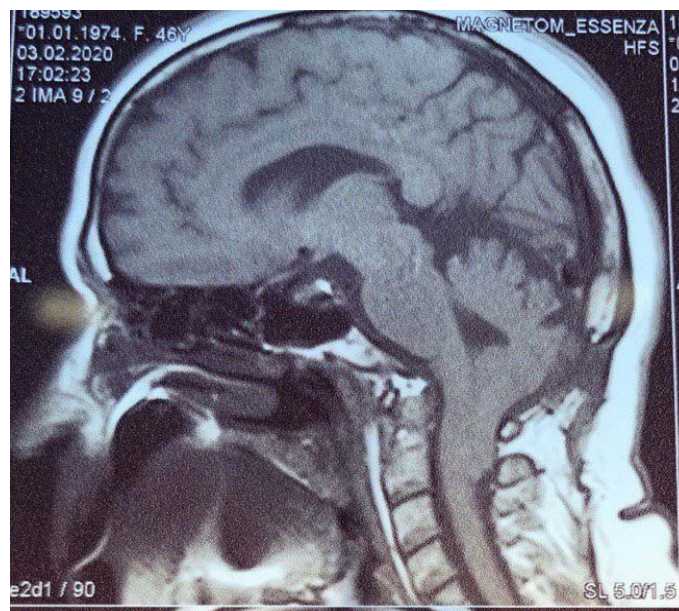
MRI of patient Z., 34 years old, with an anomaly of the craniovertebral junction with displacement of the cerebellar tonsils below the Chamberlain line up to 24 mm from 2 sides
